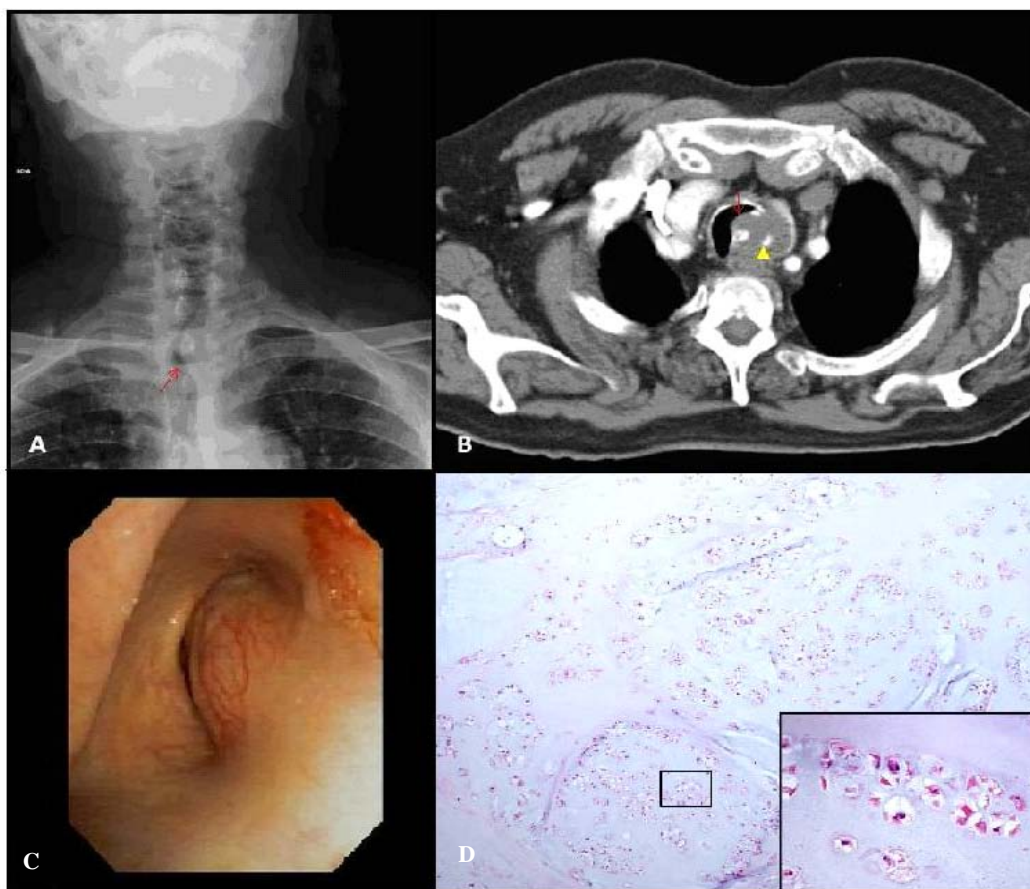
A) The chest radiograph shows a narrow cervical tracheal lumen (arrow). B) CT scan with intravenous contrast shows a 45 mm mass with calcifications on its greatest diameter. The tumor depends on the left posterolateral tracheal wall and significantly narrows the airway. C) Endoscopic image showing the most cranial part of the tumor obstructing almost all of the tracheal lumen. D) Moderately hypercellular cartilaginous neoplasm with proliferating pattern. Inset: clusters of cells with round and polygonal cytoplasm, nuclear hyperchromasia, showing frequent binuclear cells.
